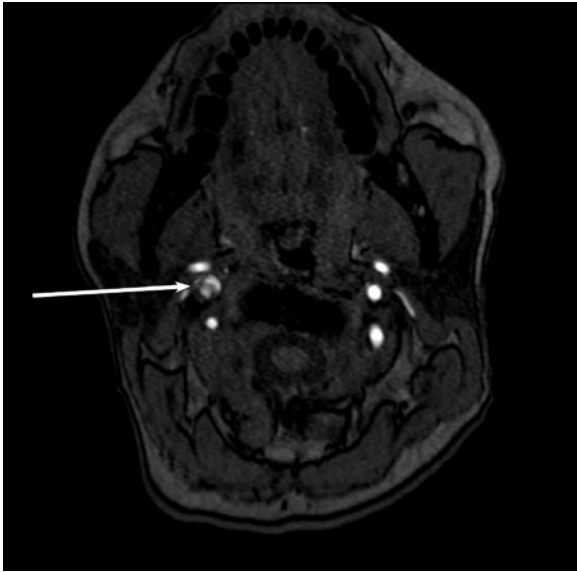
MRI (axial image) showing right internal carotid artery dissection with high grade stenosis.
